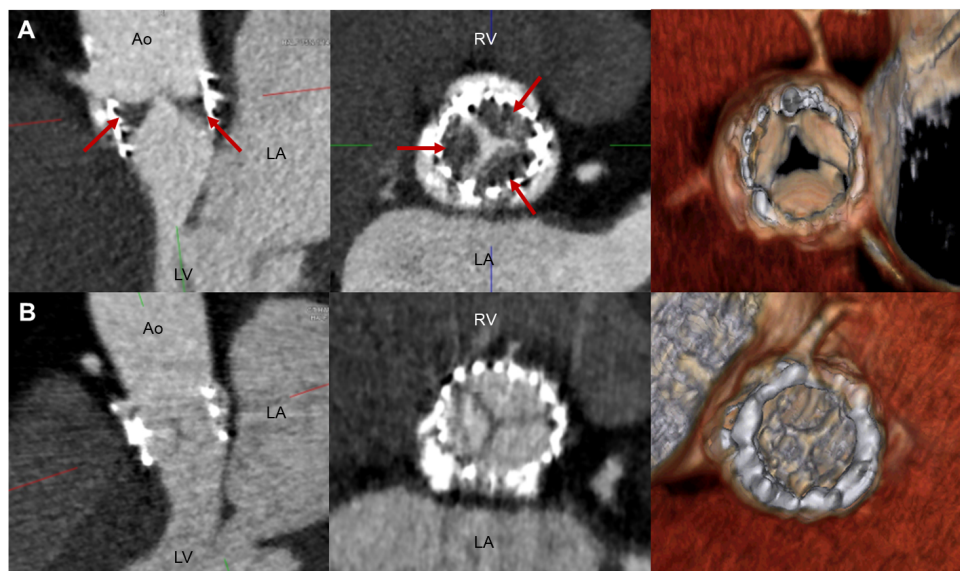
Four-dimensional multidetector row computed tomography reconstructions after TAVI of a patient with hypo-attenuated leaflet thickening (HALT) with reduced leaflet mobility (*panel A*) and of a patient without HALT (*panel B*). The red arrows depict the hypo-attenuated lesions suggestive of the presence of subclinical leaflet thrombosis. Ao, aorta; LA, left atrium; LV, left ventricle; RV, right ventricle; TAVI, transcatheter aortic valve implantation.
